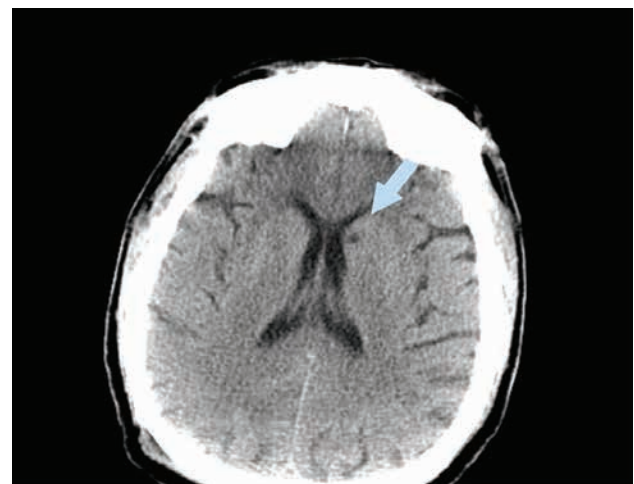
CT scan showing hypodense area at the head of the left caudate nucleus (arrow)
